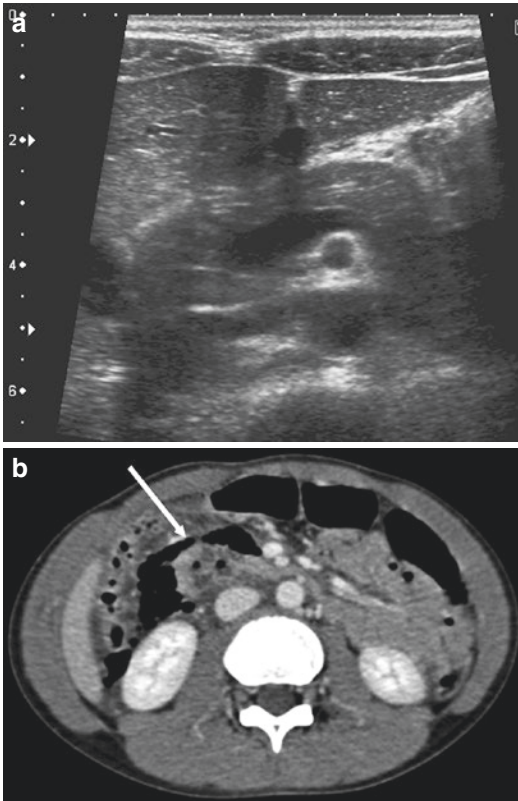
Seven year old boy. Bike injury with direct epigastric trauma by the handlebar. (a) Initial US shows only a moderate fluid effusion without pancreatic anomaly. (b) CT with contrast: done because of the abdominal pain with abdominal contracture. It shows duodenum perforation (D2-D3) (*white arrow*)
